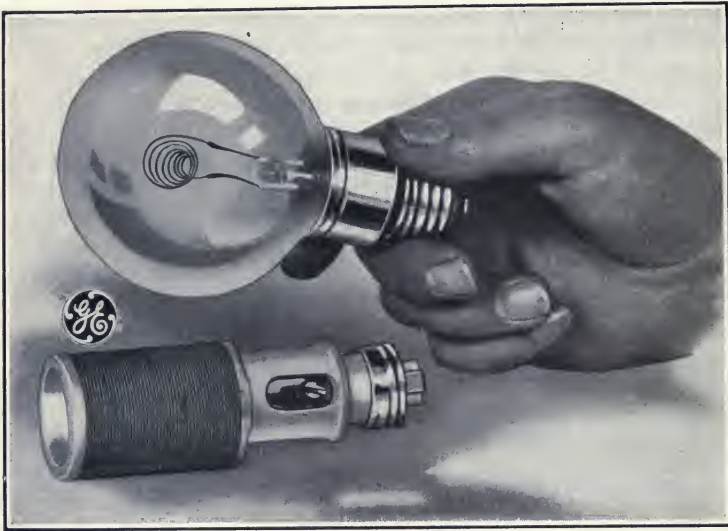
Interchangeable incandescent bulb and infrared unit. (Courtesy of the General Electric X-ray Corporation.)
